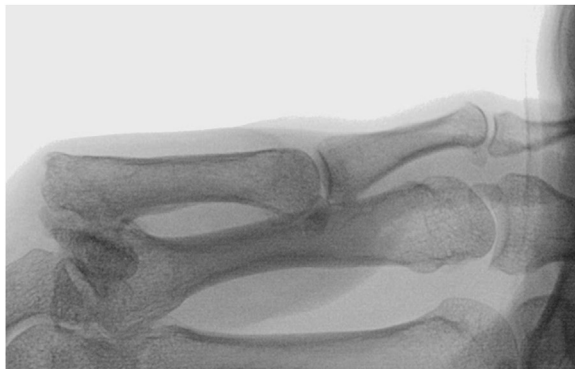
Lateral radiograph of severe trapeziometacarpal osteoarthritis with chronic dorsal subluxation of the base of the first metacarpal and erosion of the dorsal side of the trapezium (left). Postoperative situation with correct conical cup centering and inclination. Due to insufficient bone stock, the dorsal side of the cup is partially exposed (right).
